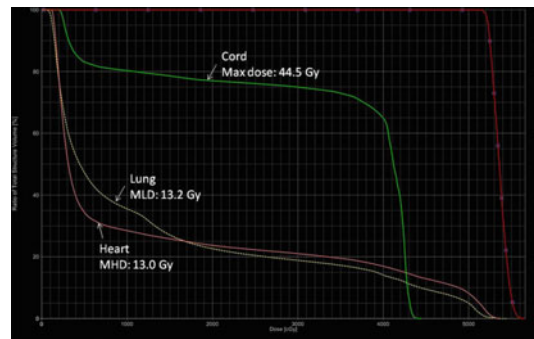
The planning CT, with IV contrast, was fused with the PET-CT showing refractory disease after 2 cycles of salvage R-ICE chemotherapy. The CTV was the same
